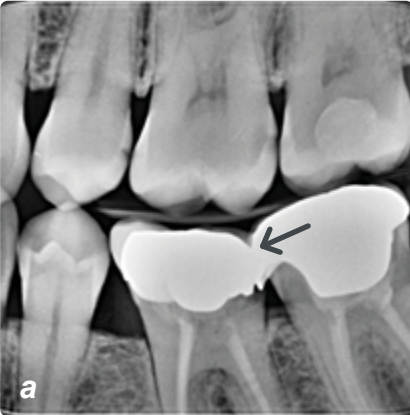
a: X-ray bite-wing diagnosis of the distal caries on tooth 26 (arrow)
